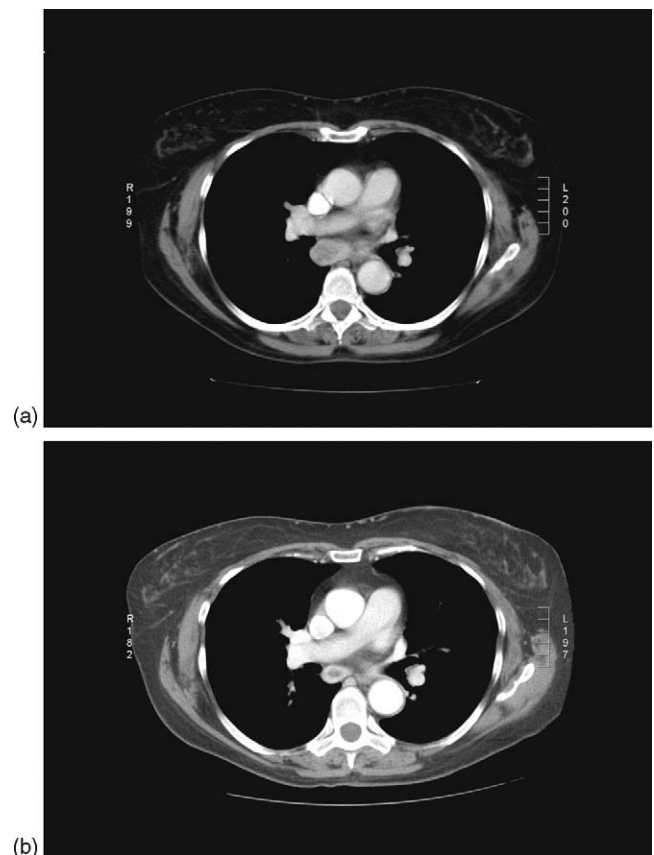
(a) Computed tomography scan showing mediastinal lymph node metastases; (b) evidence of significant reduction after 8 mo of treatment with open-label everolimus.
